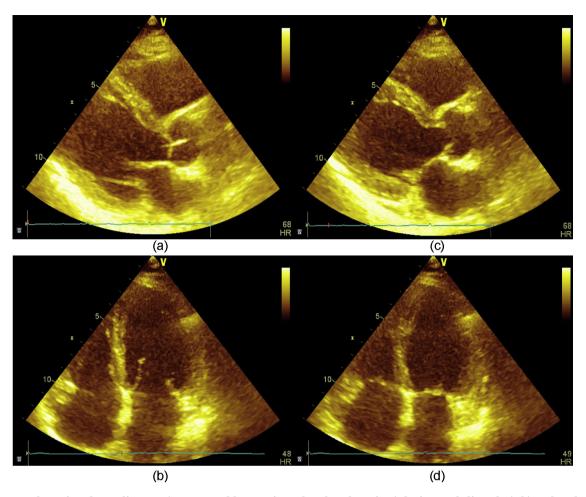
Transthoracic echocardiogram (parasternal long axis and 4-chamber view) during end-diastole (a,b) and end-systole (c,d) shows basal and midventricular segmental hypokinesis of the left ventricle with a well-preserved apical segmental systolic function.
